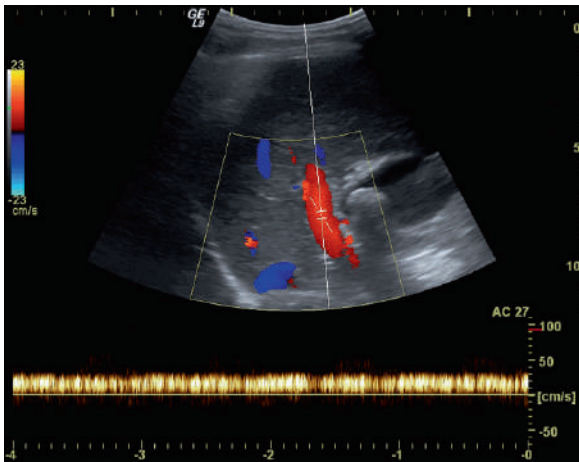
Color Doppler waveform spectrum of the portal vein shows the normal monophasic pattern
